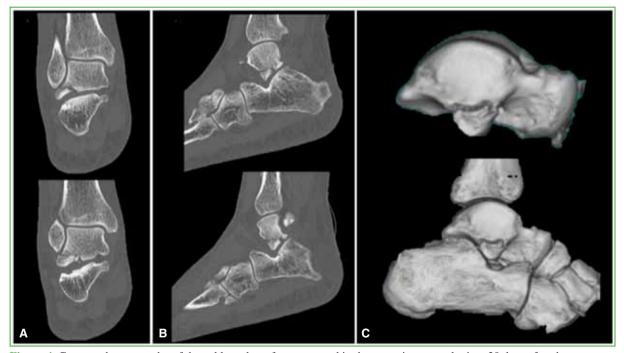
Computed tomography of the ankle and rearfoot requested in the outpatient consultation, 20 days after the accident. A. Coronal slices. B. Sagittal slices. C. 3D reconstruction.
